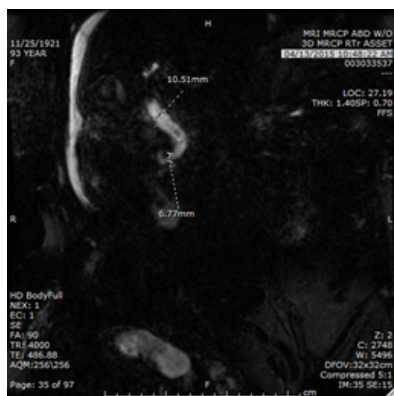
MRI MRCP ABD W/O (3D MRCP RTr Asset).
